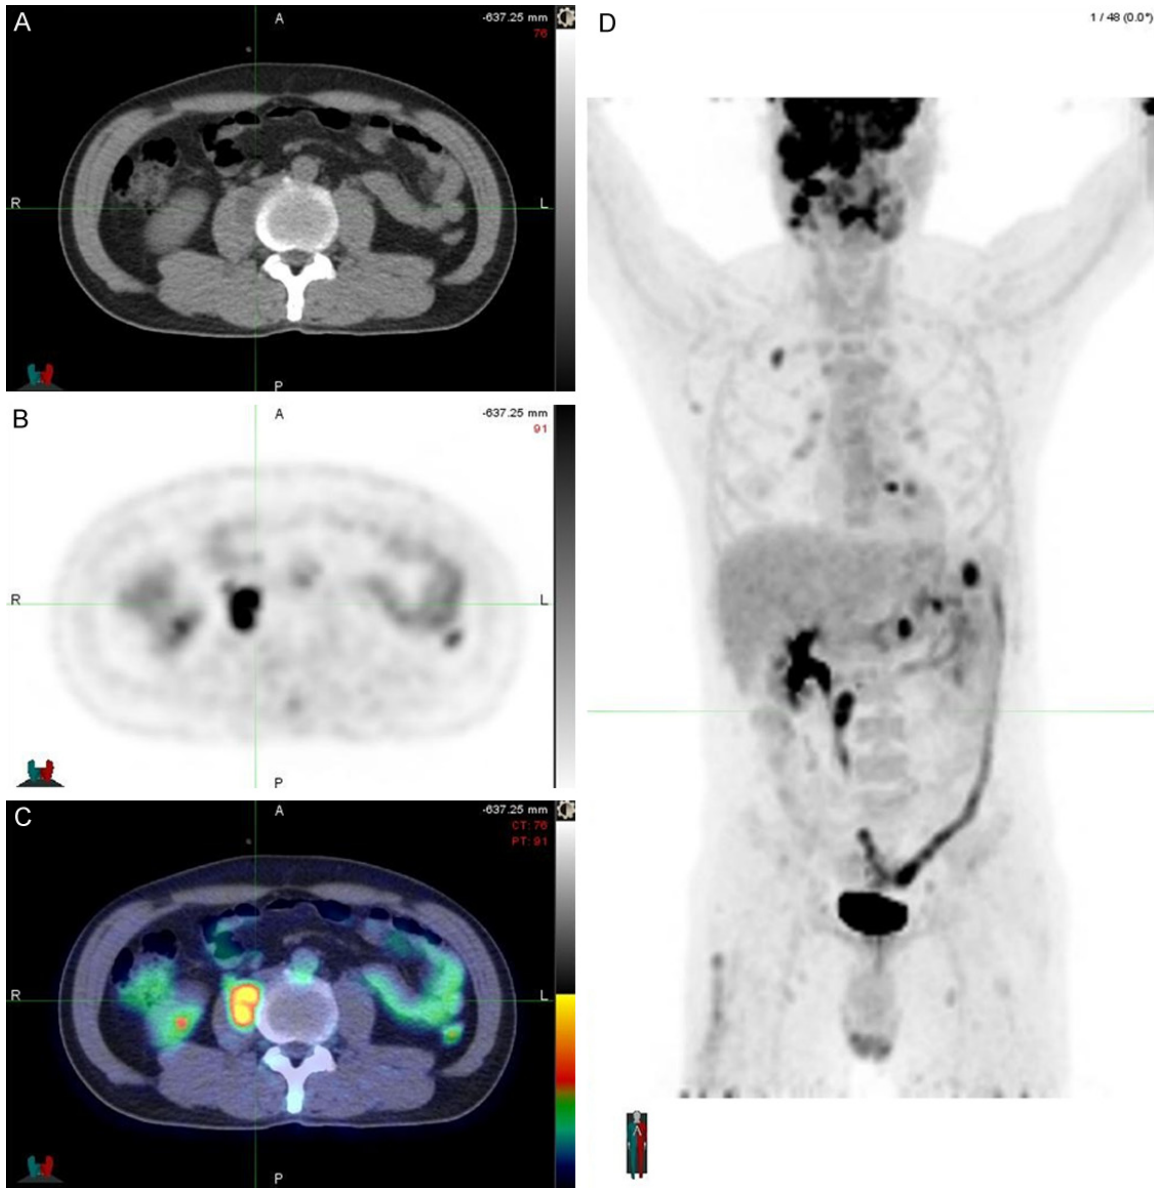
Initial PET/CT done during radiation therapy shows spread of the disease beyond the primary tumor. Increased uptakes are noticeable in the head, upper right lung, upper left abdominal quadrant and right psoas (D). Uptake in the descending colon was interpreted as physiologic. Axial CT (A), PET (B) and fusion (C) images show in more detail the lesion described in the psoas, which is slightly noticeable in the CT image (A) as a less hypodense structure inside the psoas and presents homogeneous FDG uptake in the PET image (B).
